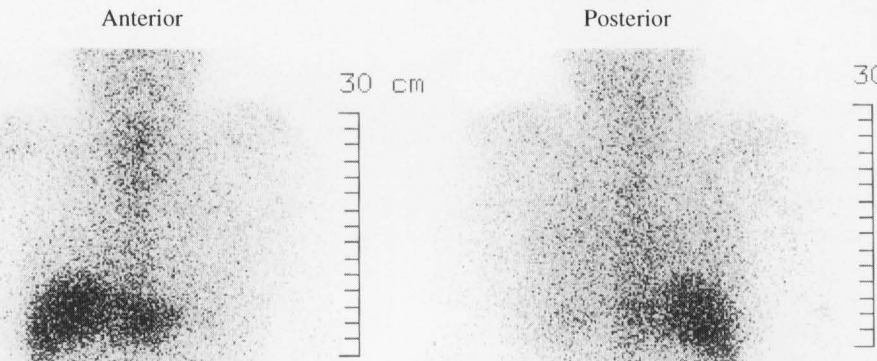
Rest Ga-67 scintigraphy does not show significant increased uptake in the heart after the treatment with prednisolone.
